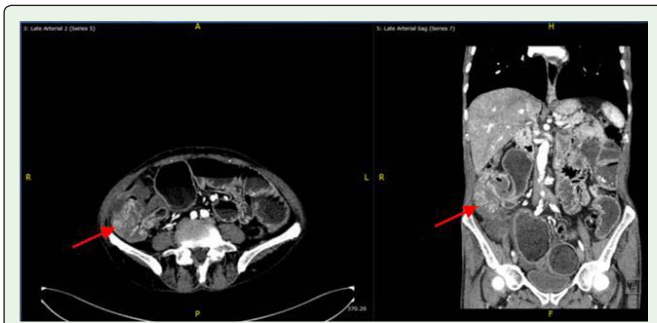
Abdominal computed tomography scan revealing a mass in the cecum and proximal ascending colon.
